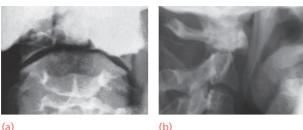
Fractured odontoid process (a) Anteroposterior 'open-mouth' X-ray showing a type II odontoid fracture. (b) Lateral X-ray of the same patient.
